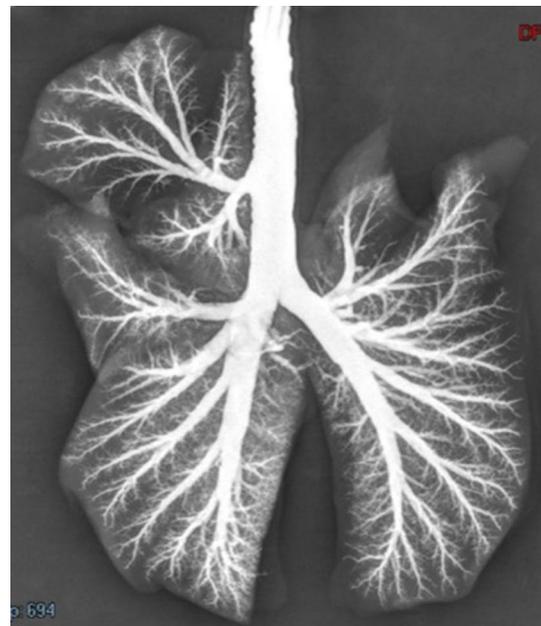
Lung bronchography radiographs taken after barium injection
